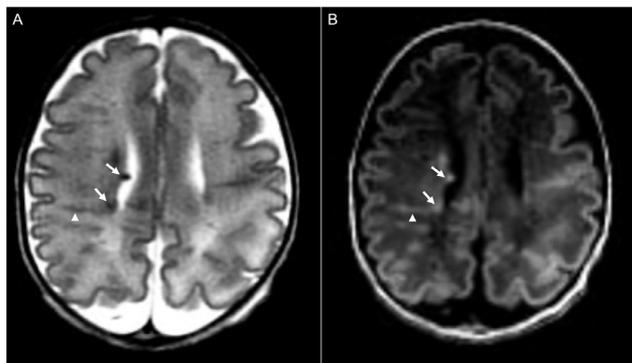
A 14-day-old female patient. Brain MRI axial T2w sequence (A) shows 2 hypointense subependymal nodules (white arrows) and 1 hypointense radial migration line (white arrowhead) that appear hyperintense on axial T1w sequence (B).
